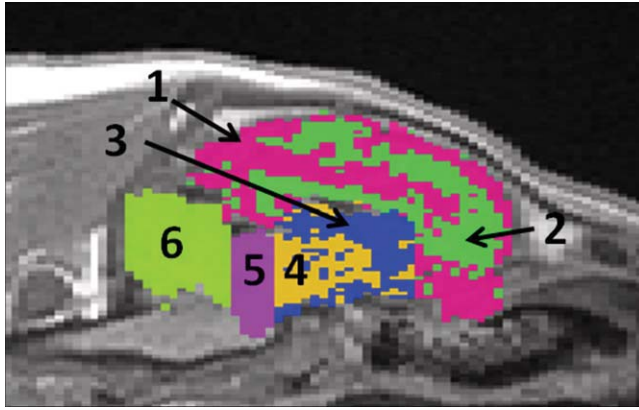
Sagittal T1-weighted anatomical MRI with tissue regions-of-interest overlaid, including 1: cortical gray matter (GM); 2: cortical white matter (WM); 3: deep GM; 4: deep WM; 5: mesencephalon; and 6: cerebellum. The image was cropped to isolate the brain. [Color figure can be viewed in the online issue, which is available at wileyonlinelibrary.com.]
